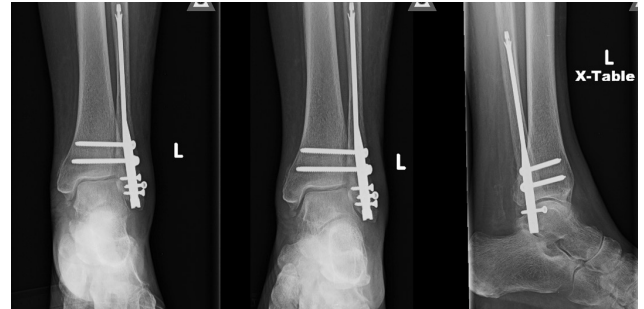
Four-month follow-up X-rays
